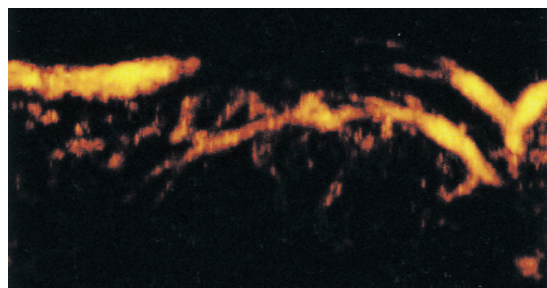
3D power Doppler image.
